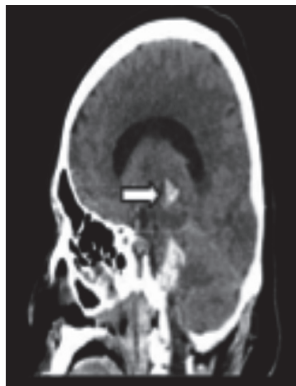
(A): Sagittal Plain CT Brain Image Showing Hyperdense Areas in the Left Thalamus
